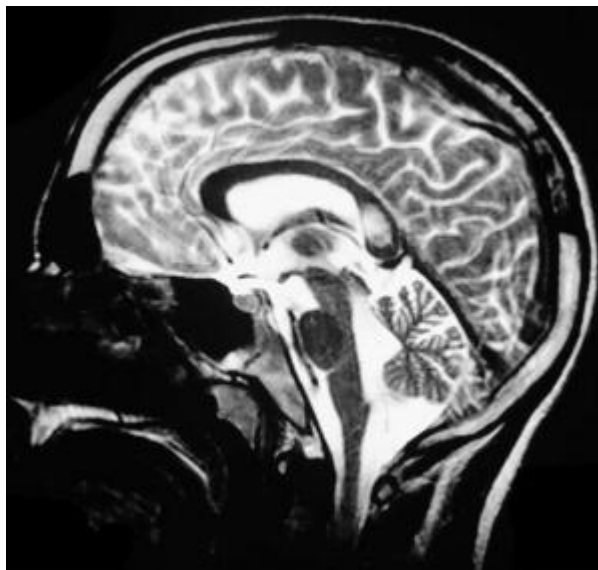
T2-weighted image showing haemorrhagic injury in the mid-brain and pons
